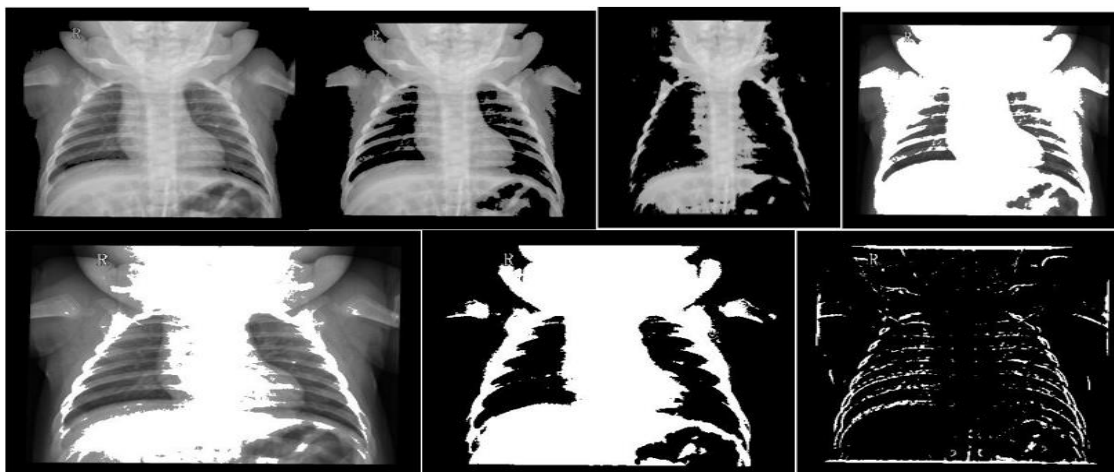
(b): chest radiograph basic thresholding; from left, threshold image with black reduced to 20%, threshold image with black reduced to 40%, threshold image with black reduced to 60%, threshold image with white reduced to 40%, threshold image with white reduced to 60%, threshold image with black and white reduced to 50% each and adapted threshold image
